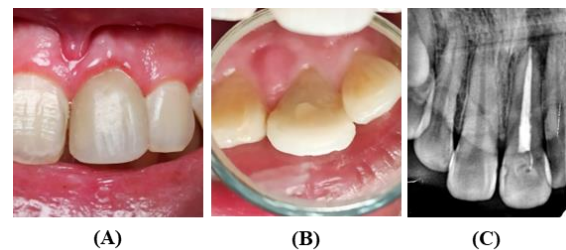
Two Month Control, Labial (A), Palatal (B), Radiograph Examination (C)
